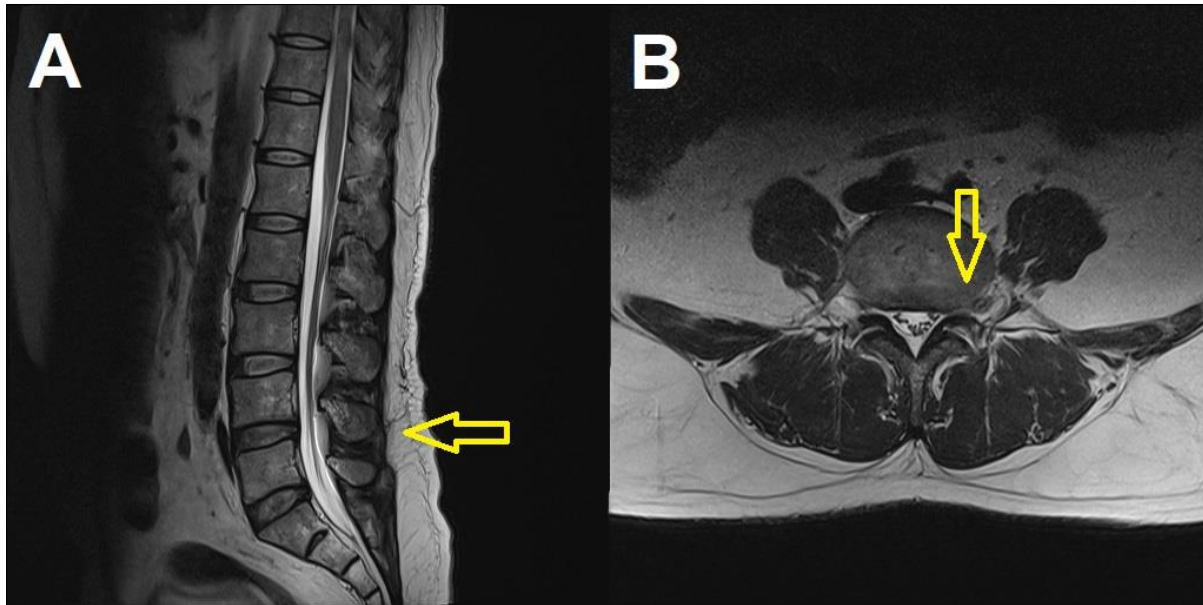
(A) Sagittal T2-weighted image shows no epidural hematoma, central canal compression, or acute cauda equina compression. (B) Axial T2-weighted image at L4–5 shows left extraforaminal disc extrusion with involvement of the exiting left L4 nerve root. Additional reported MRI findings included L3–4 disc bulging and left subarticular L5–S1 disc extrusion affecting the left S1 nerve root.
